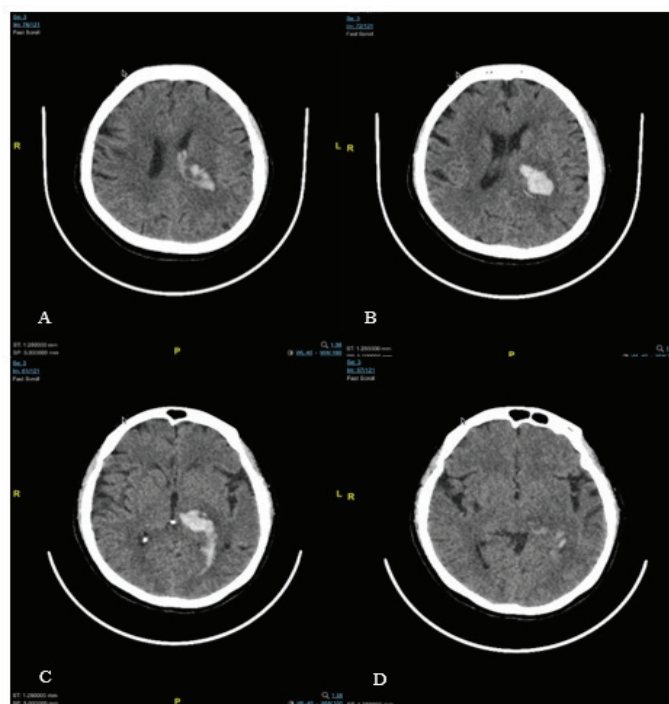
A-D: Brain CT Scan (without contrast). Left Thalamic Hemorrhage with Perifocal Edema and Intraventricular Extension to The Left Lateral Ventricle, Plus Chronic Right Corona Radiata Infarct and Cerebral Atrophy
